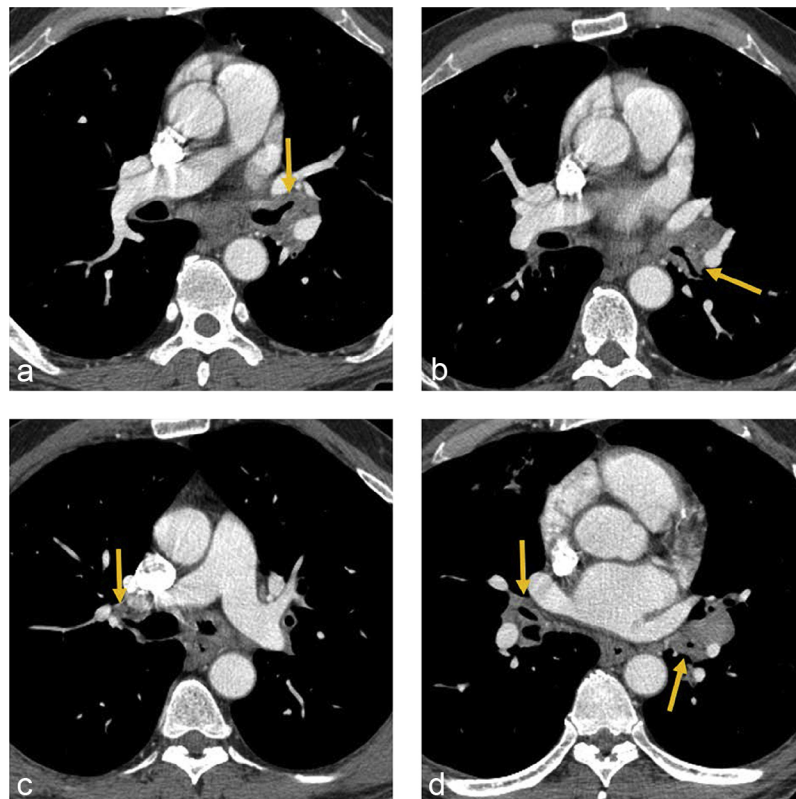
Contrast-enhanced axial CT images of the chest at the level of the left lingular and left lower lobe superior segmental bronchus (A, B) show diffuse wall thickening within these airways. (C, D) Diffuse wall thickening within the right upper lobe, right middle lobe, and left lower lobe bronchus.
